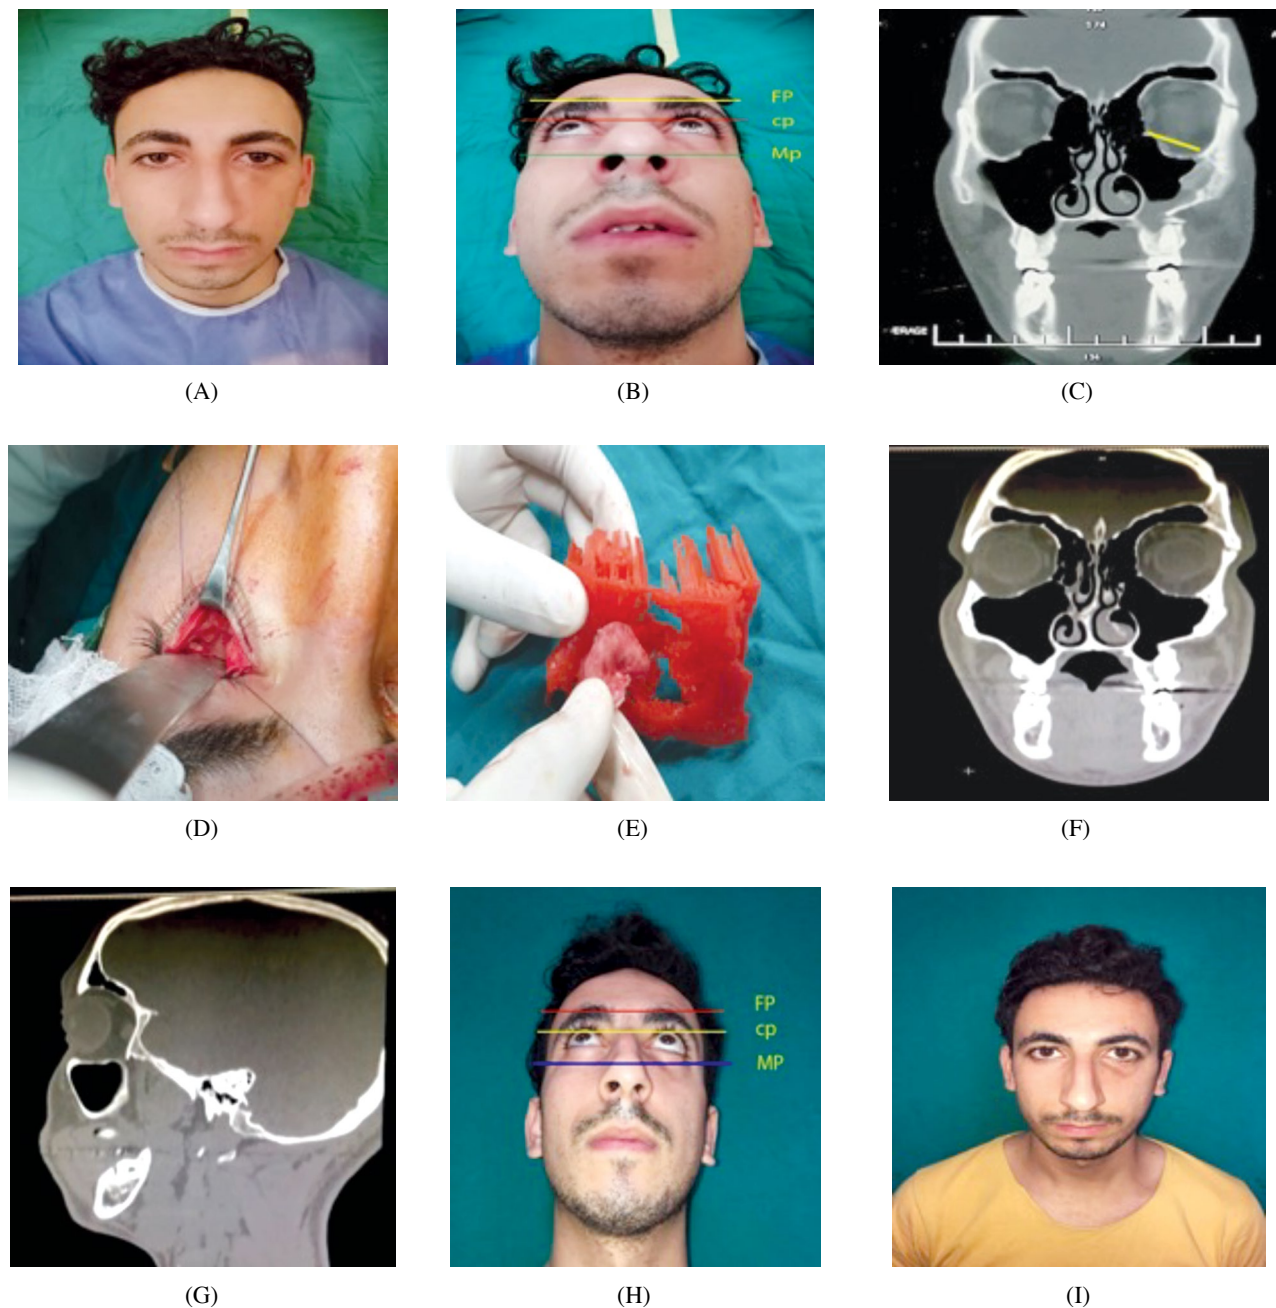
Male patient 22 years old with a history of road traffic accident associated with left orbital floor fracture, inferior orbital wall, and lateral orbital wall delayed one month. The patient was admitted to our center one month after trauma complaining of diplopia in an upward gaze direction. A 3D module was printed, and reconstruction was done by conchal cartilage graft. (A,B) Preoperative anterior and inferior clinical views of the patient showing no enophthalmos of the left eye (CP: Corneal plane, MP: Maxillary plane, FP: Frontal plane). (C) Coronal CT radiological showing fracture of left orbital floor and lateral orbital wall with soft tissue herniation. (D) Intraoperative clinical view showing left orbital floor fracture. (E) 3D printed model with conchal cartilage graft molded to fit the size and shape of fracture. (F,G) Postoperative CT coronal and sagittal views respectively showing repair of the left orbital floor without herniation of orbital soft tissue. (H,I) Anterior and inferior clinical views respectively after 6 months.
